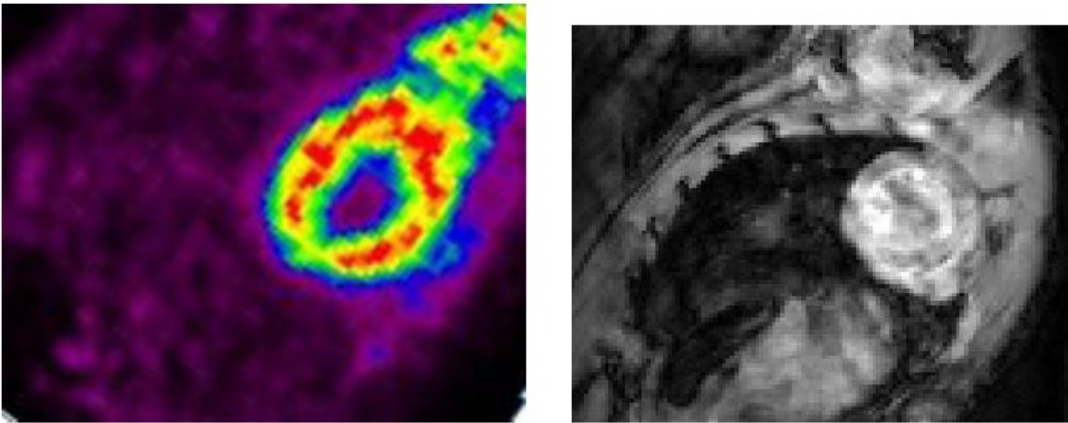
Simultaneous PET-MRI (Gradient Echo with 30 ms TR and 3.3 ms TE) images, no gating was used, ~50 million prompts collected for the PET image.
